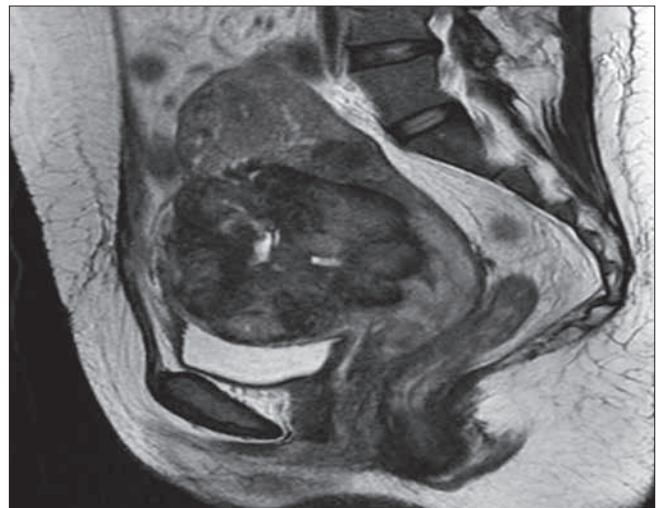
MRI shows the placenta percreta before the treatment. The sagittal T2-weighted cross-section noncontrast image shows the heterogeneous intensity and lobulated contoured mass lesions, consistent with placenta percreta, along the anterior-inferior of the uterine corpus.
